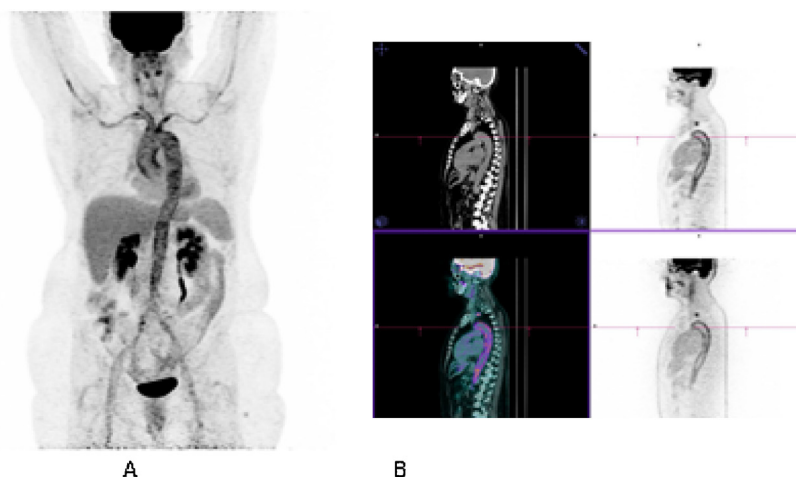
A. MIP (maximum intensity projection): FDG-PET images in a 65-year-old female patient showed increase FDG uptake in the vessel wall of the aorta and supra-aortic branches suggestive of giant cell arteritis. B. Sagittal CT, PET and PET/CT slices located on the chest.
